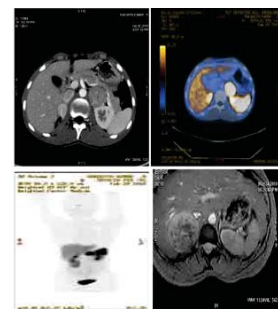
Computed tomography images enhanced with contrast that display bilateral adrenal tumours
